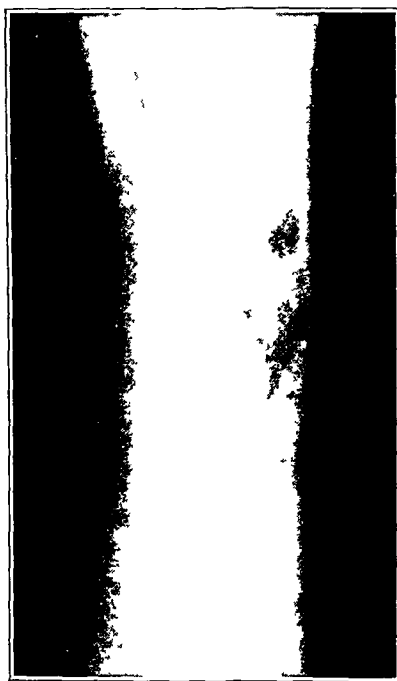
(path. no. 37614).—Roentgenogram of a femur showing the osteolytic form of osteogenic sarcoma, not infrequently confused with the roentgenographic picture of metastatic carcinoma.
